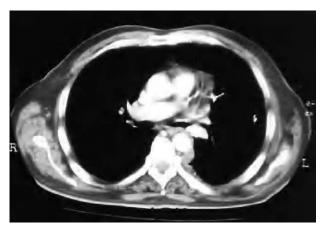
Chest computed tomography scan showing stenosis caused by a tumoral growth in segment VI of the bronchus.
